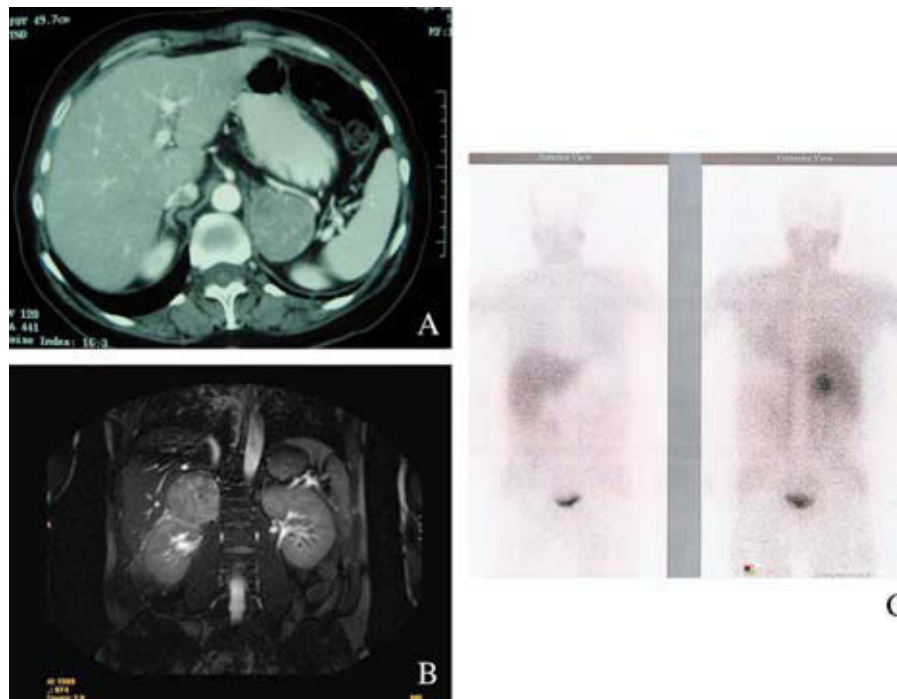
A) CT image of a left adrenal mass. B) MRI showing a left pheochromocytoma lesion. C) Adrenal metaiodobenzylguanidine scan.
